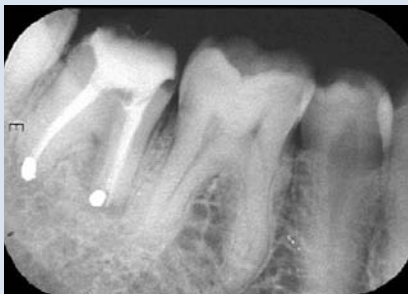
IOPA radiograph taken in 1984, 6 months after the intentional replantation, shows slight resorption of the mesial root. Retrograde amalgam fillings were placed and the coronal pulp chamber was sealed with amalgam. No biomechanical preparation was done.
